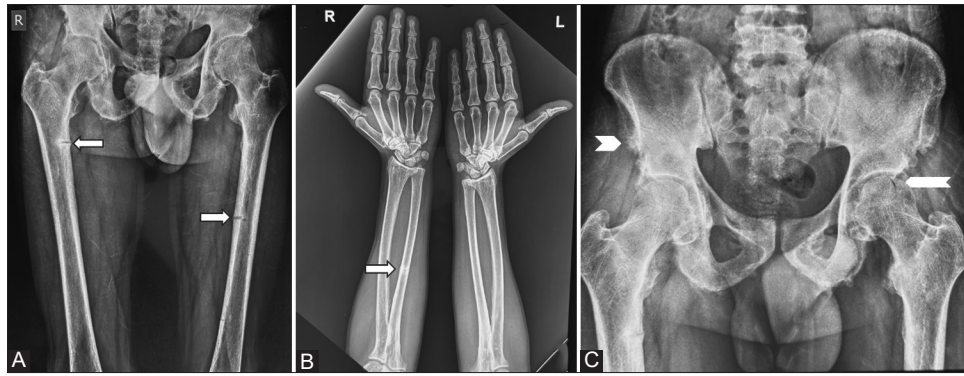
X-ray of the pelvis and forearm showing pseudo-fracture due to hypophosphatemia (Panels A and B, respectively) and extensive enthesopathy in the pelvis (Arrowhead, C panel)
